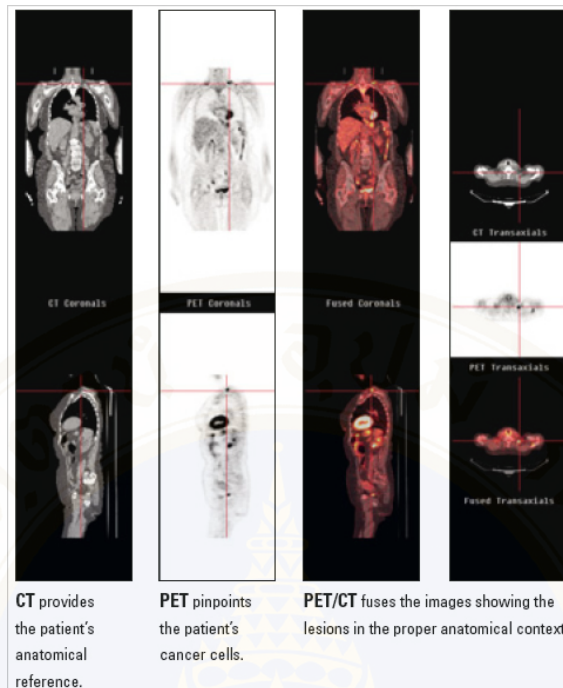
The example of all image planes from PET/CT : coronal plane(above), sagittal plane(below), transaxial plane(right)
